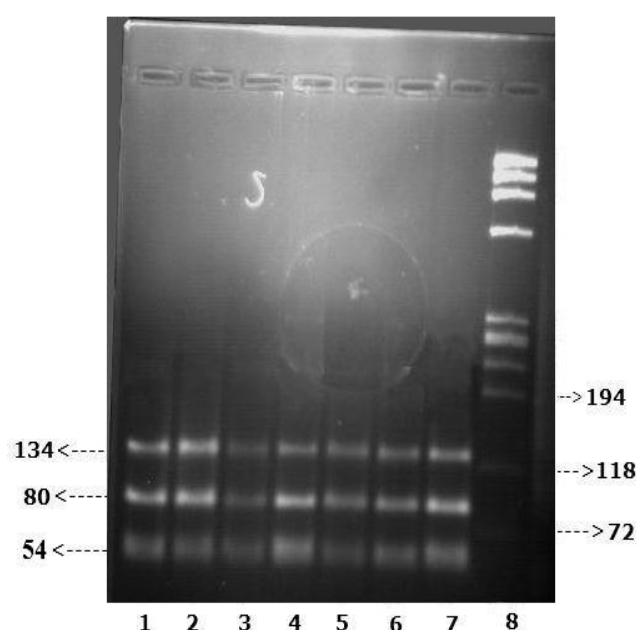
SUR-1 exon 16 -3C/ T genotypes: Lane (8): \emptyset x174 DNA/BSUR1(HaeIII) Marker, Lane (1, 2, 3, 4, 5, 6, and 7): HYPCH4V enzyme restricted PCR product into heterozygous CT genotype of SUR-1 exon 16 -3C/T as it was restricted into 134, 80, 54bp.
